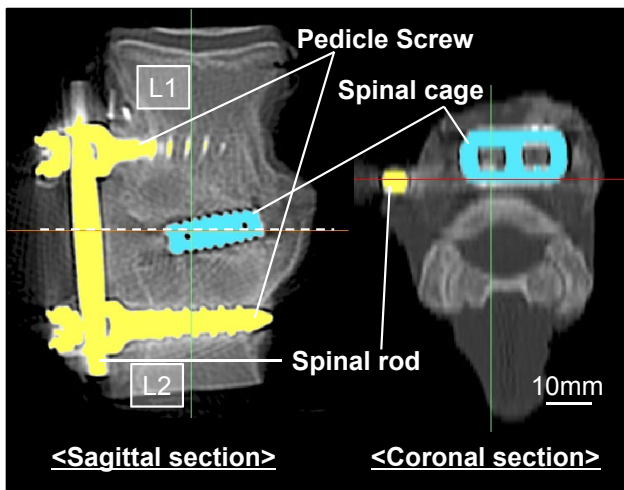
Computed tomography images of spinal cage after implantation into the intervertebral space.
